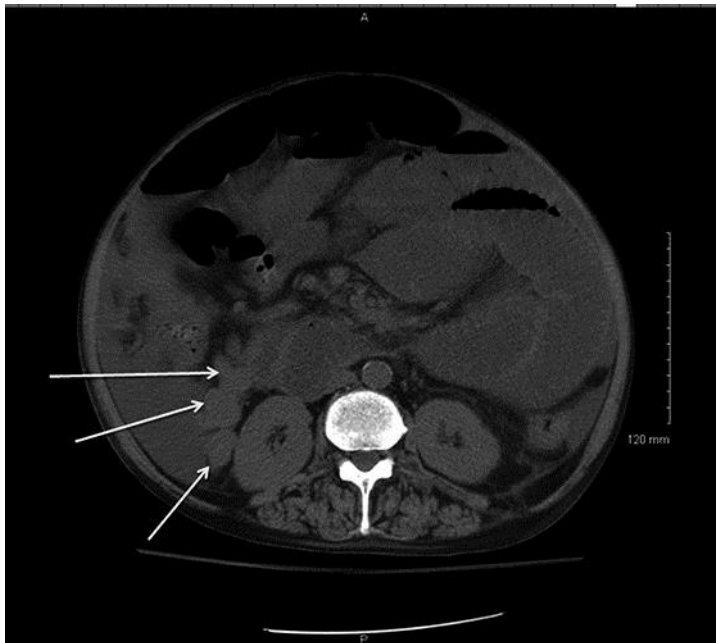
Noncontrast CT scan transverse image of the abdomen in a 46-year-old man with HHT and alcoholic cirrhosis hospitalized with abdominal pain and fever. This image reveals marked distention of the small intestine, air-fluid levels in the small intestine, absence of free air in the peritoneum, and multiple large varices adjacent to the right kidney (arrows).
